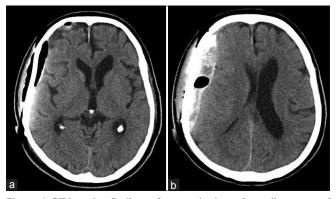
CT imaging findings after cranioplasty. A small amount of air is the sole abnormal finding immediately after cranioplasty (a). Epidural hematoma is evident under artificial bone at 22 hours after cranioplasty (b)
